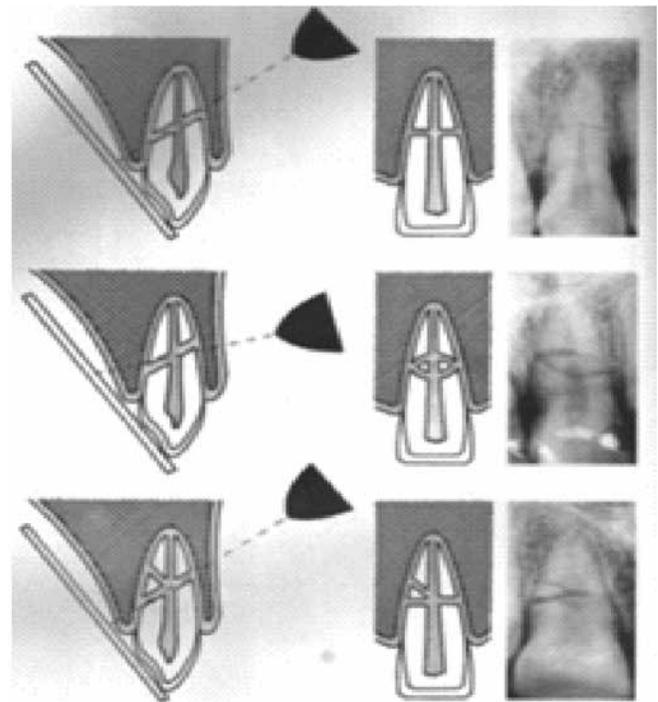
Radiographic demonstration of root fractures. The normal projection angle is parallel to the fracture surface, resulting in a single transverse line on the radiograph. Decrease or increase of the projection angle results in an ellipsoid fracture line on the radiograph. The fracture line in multiple root fractures shows an irregular shape on the radiograph
